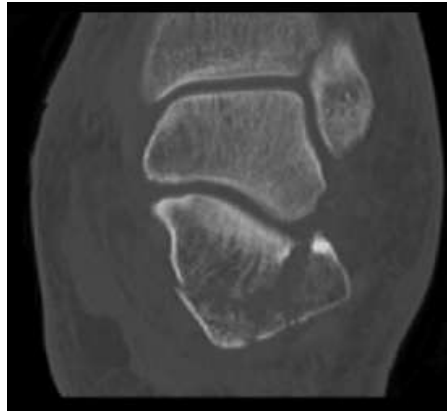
Coronal CT scan demonstrating Sanders Type III fracture with comminution of the posterior facet and associated lateral wall blowout.
